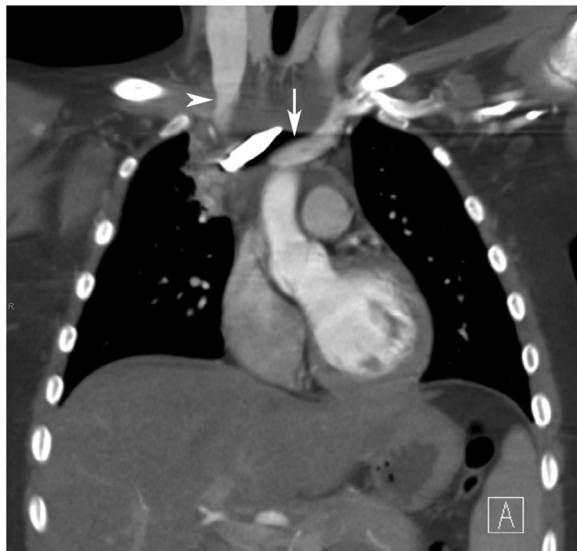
Coronal computed tomography (CT): Coronal CT of the chest with intravenous contrast in the coronal plane. The penetrating foreign body extends into the mediastinum and has narrowly missed the left innominate vein (marked with an arrow). The bolt head is just anterior to the right innominate vein (marked with an arrowhead). The adjacent aortic arch (inferior to the left innominate vein) and its cervical branches (specifically the right brachiocephalic artery) were in close proximity to the foreign body but were intact
